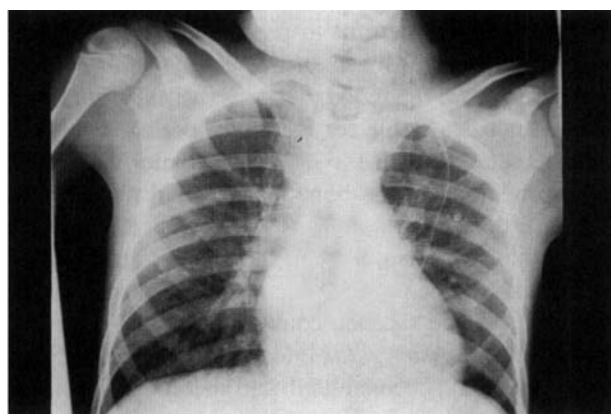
Radiograph of the lungs, 18 days after first positive blood culture.
